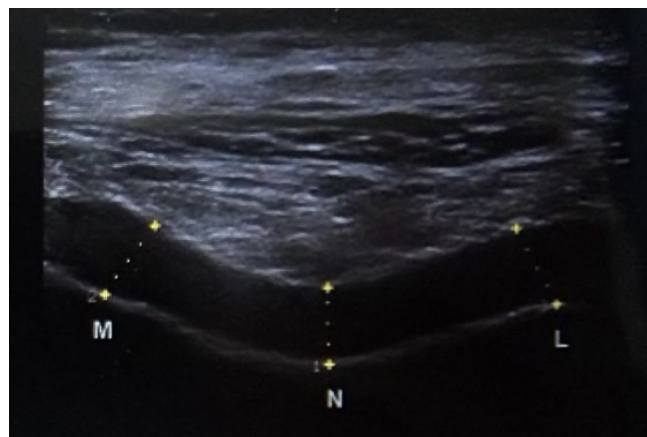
Cartilage ultrasonographic normal.
